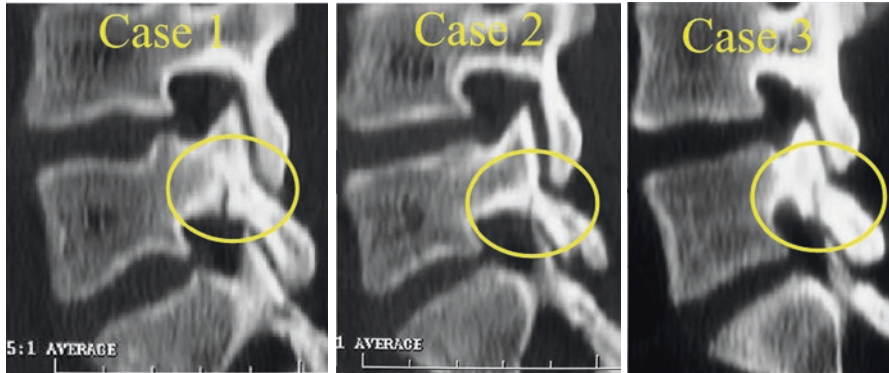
Sagittal reconstructed CT scans in the early-stage defect
